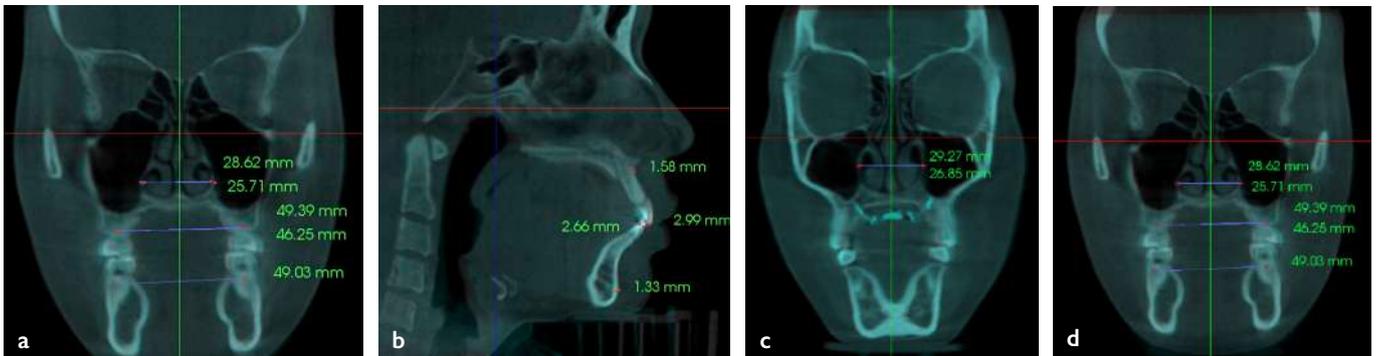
(a) The initial inter-arch width of CBCT (b) The inter-arch widths of CBCT superimposition (c) The final inter-arch width of CBCT
